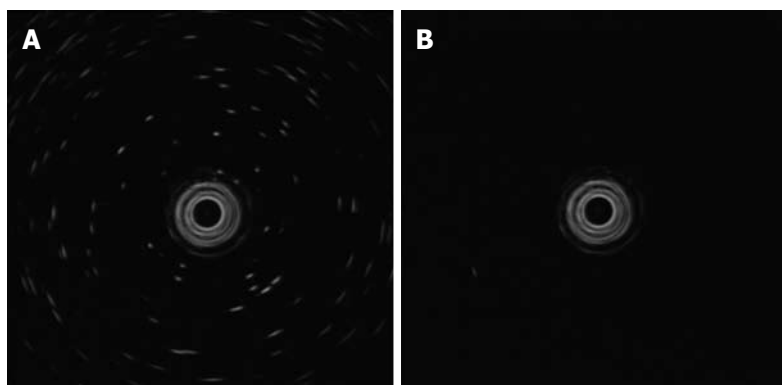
Differences in endoscopic ultrasound features with quality of water used for irrigation. A: Water from a faucet; B: Deaerated water.
